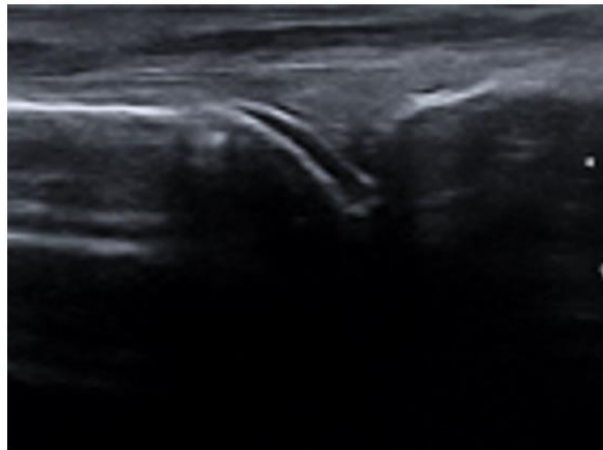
Ultrasound view of a double contour sign on a dorsal scan of a metatarsophalangeal joint
